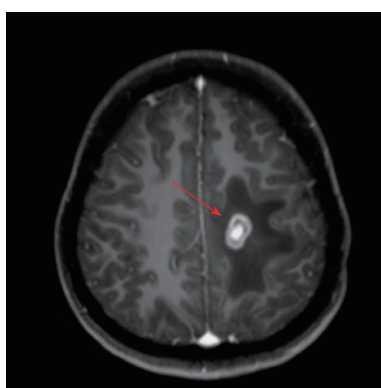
Axial T1-weighted image after administration of gadolinium-diethylenetriaminepentaacetic acid depicts prominent enhancement in the periphery and central area of the lesion.
